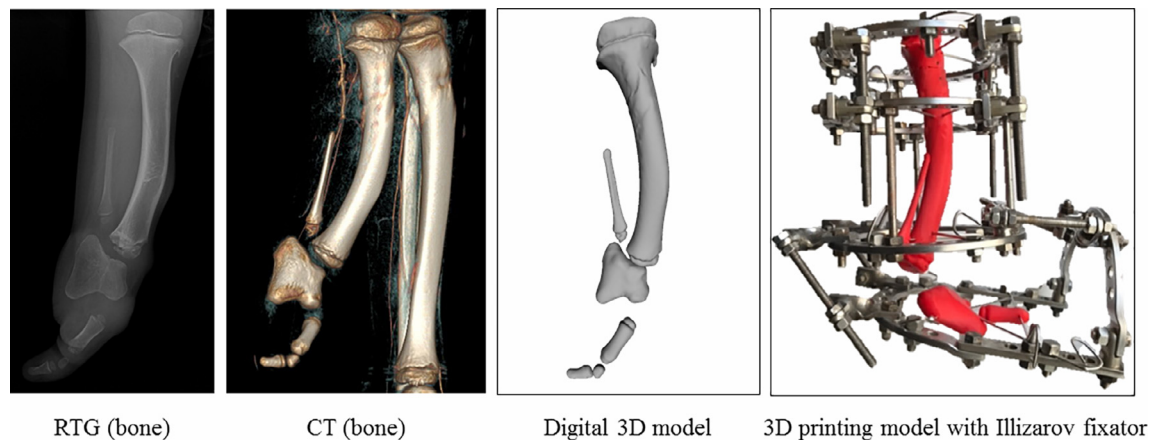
X-ray image, CT, digital 3D model and 3D-printed model with installed Ilizarov fixator.
